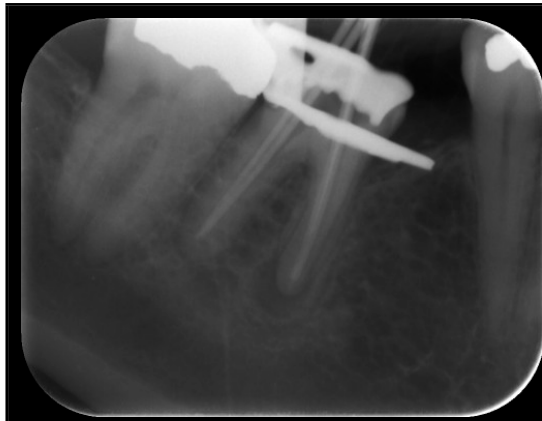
Master point radiograph
